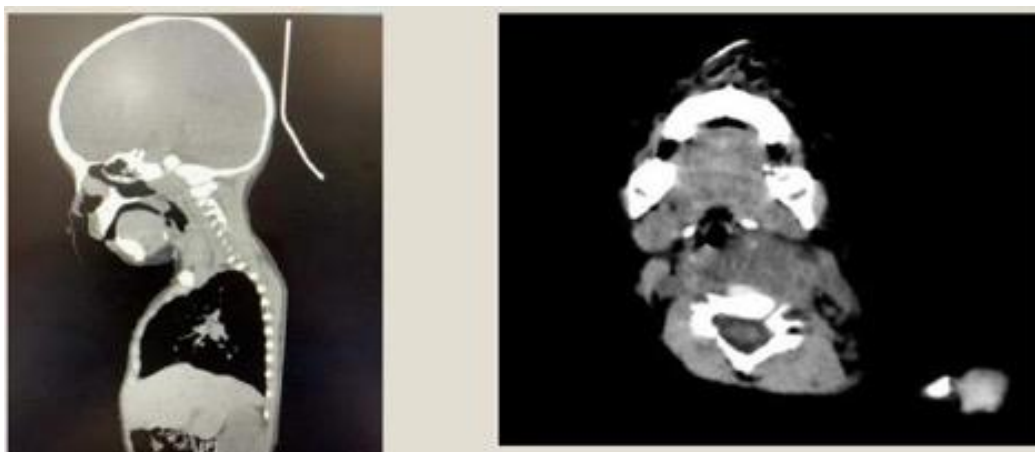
Contrast-enhanced computed tomography of the neck. Sagittal (left) and axial (right) images demonstrate a rim-enhancing retropharyngeal collection extending to the carotid space and left cervical region, abutting the left carotid artery and displacing the trachea to the right, with associated cervical lymphadenopathy.
